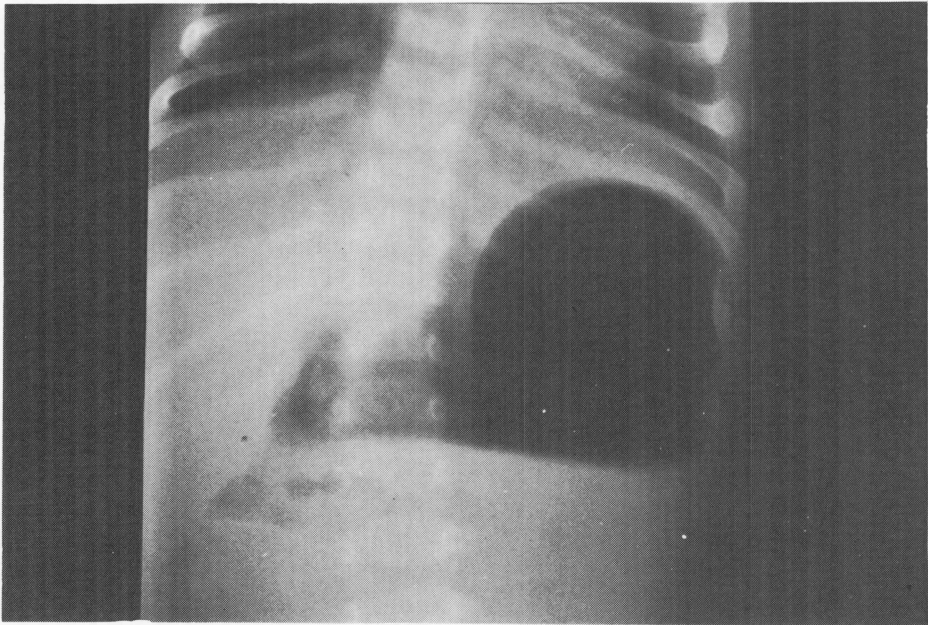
Findings on plain X-ray of the abdomen revealed marked expansion of the stomach bubble and decreased gas shadow in the digestive tract below the duodenum.
